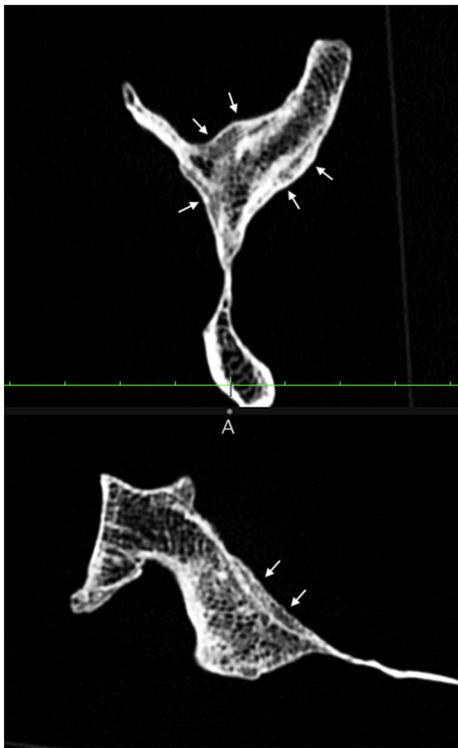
Computerized tomography (CT) multiplanar reconstruction of oblique views (sagittal and axial) of the right scapula (arrows showing areas of new bone deposition)
